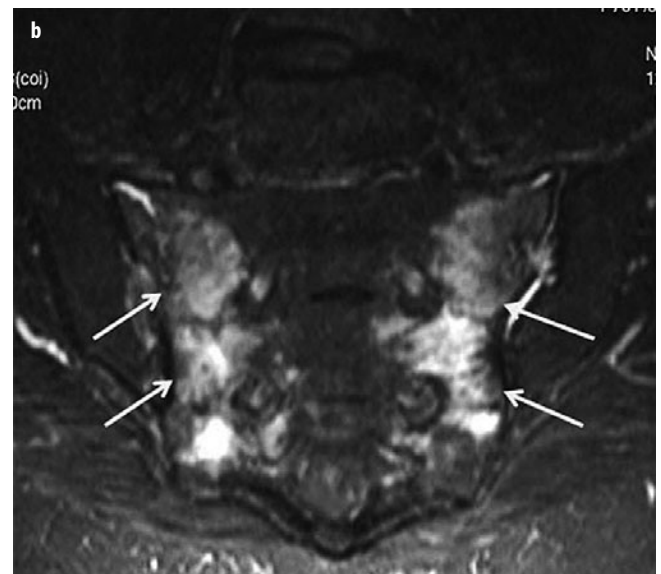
a, b. a Inclined coronal T1-weighted image and b short-tau inversion recovery (STIR) image showing bilateral sacral stress fractures postradiation therapy (arrows)
